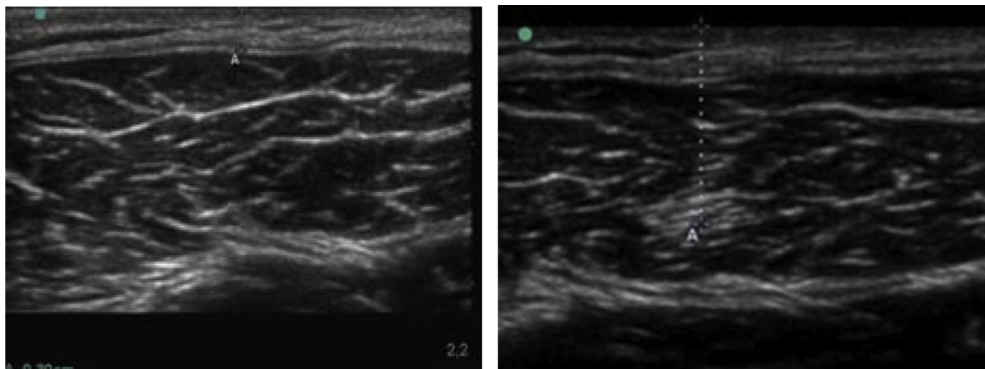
Ultrasonographic images of the skin of a normal weight male subject before (left) and after (right) injection of 0.3 mg adrenaline using the Anapen autoinjector. The dotted lines and letter A denote the skin limit (left) or the bolus localization (right).
